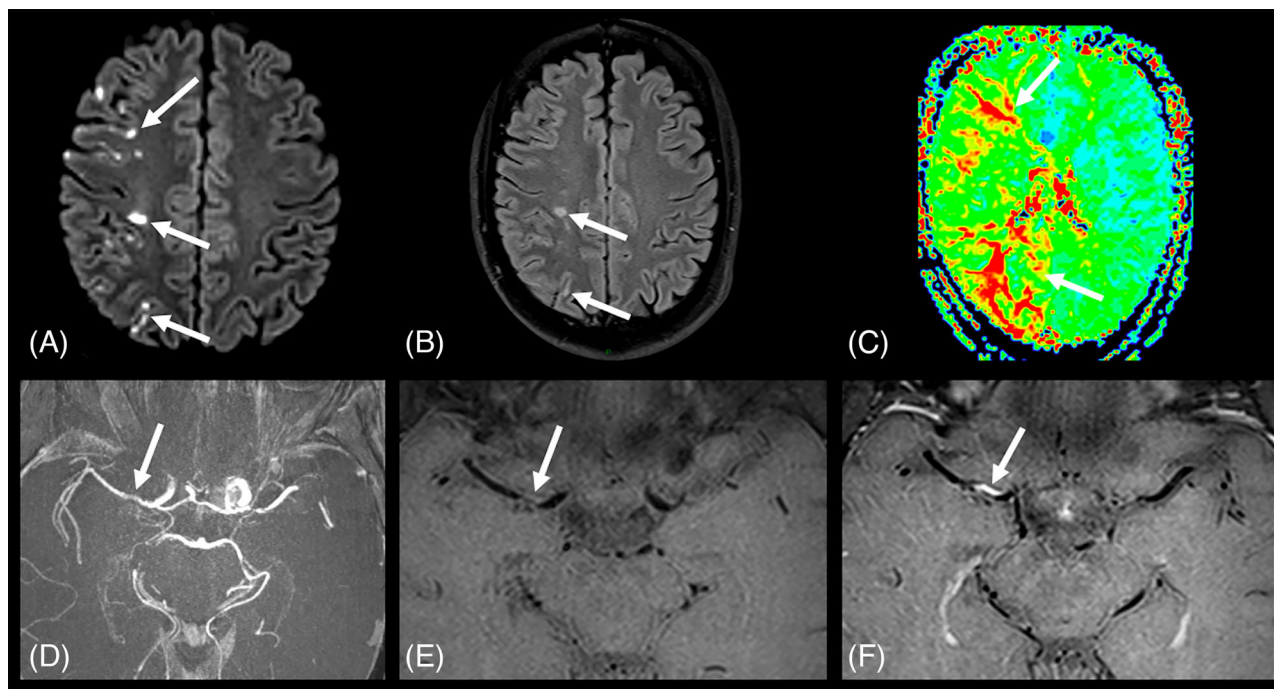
Nilotinib-associated acute stroke. Brain MRI demonstrated multiple foci of acute ischemic lesions in the right frontal and parietal lobes, with restricted diffusion (arrows in A), some with hyperintense signal on fluid-attenuated inversion recovery (FLAIR) (arrows in B), in the territory of the right middle cerebral artery. Mean transit time map demonstrated increased circulation time (arrows in C) in this territory. Magnetic resonance angiography revealed a slight irregularity in the flow signal of the middle cerebral artery (arrow in D). High resolution intracranial vessel wall imaging showed a stenosis of the M1 segment of the right middle cerebral artery (arrow in E), with eccentric gadolinium-enhancement (arrow in F), suggestive of an unstable atherosclerotic plaque.
